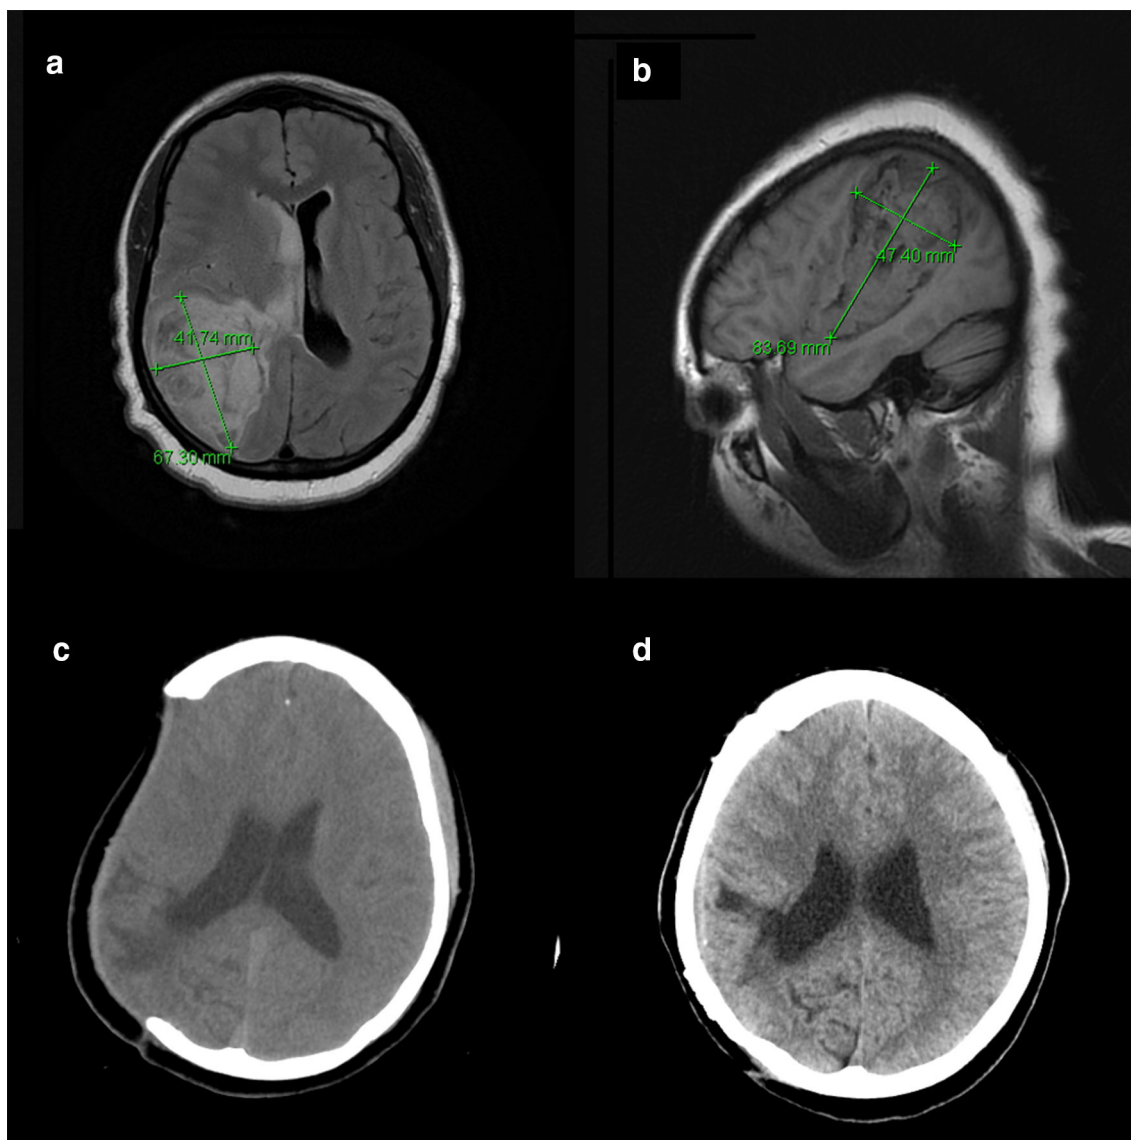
Axial (Panel a) and sagittal (Panel b) MRI sequences at admission show a right parietal and temporal IPH with intraventricular extension. Panel c shows an MRI post-right hemispherectomy for
